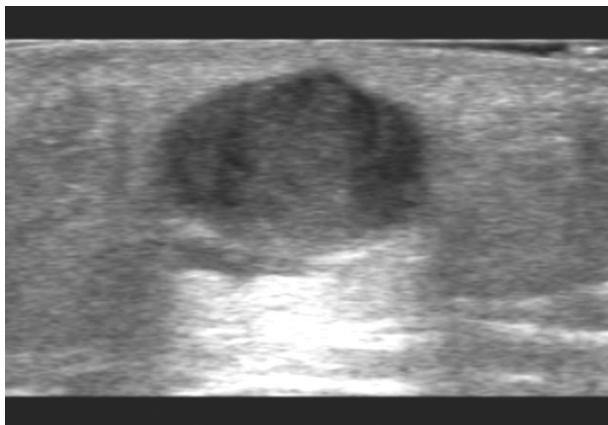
Ruptured epidermal inclusion cyst in a 23 year old woman with a palpable abnormality. The ultrasound exam demonstrates a hypoechoic lesion. Since the abnormality did not represent a simple cyst or a prominent but normal ridge of breast tissue, it was surgically excised, and the pathologic diagnosis was a ruptured epidermal inclusion cyst.
